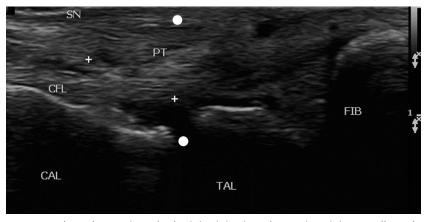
Anterolateral posterior subtalar joint injection, short axis to joint, needle path out of plane with transducer. Dots represent path of needle. Each dot signifies a pass of the needle tip below the ultrasound beam. The needle is directed along a steeper trajectory with each pass until the tip is visualized within the joint space. The crosses indicate the distance between sural nerve and joint space. Left, inferior; right, superior. CFL, calcaneofibular ligament; FIB, lateral malleolus of fibula; PT, posterior tibial tendon; SN, sural nerve; TAL, talus.
